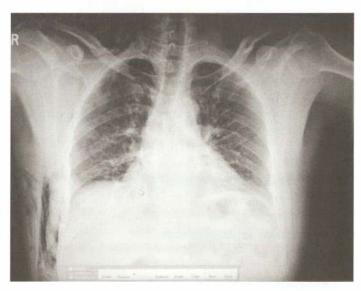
Chest X-ray showing 10th rib fracture with surgical emphysema on the right side
